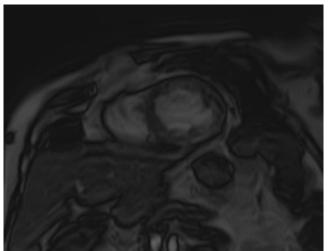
Cardiac MRI with appearance of late intramyocardial enhancement
